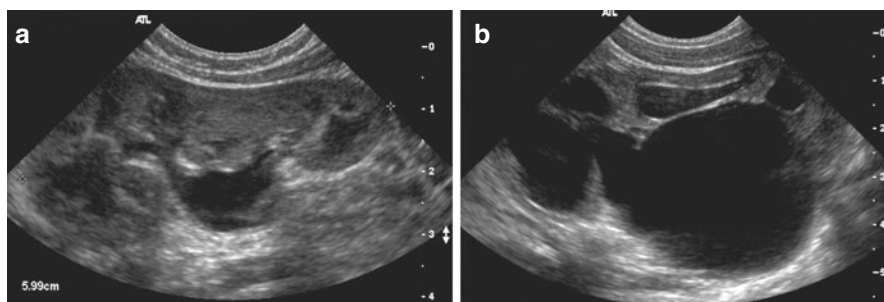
Renal ultrasound demonstrating (a) mild right hydronephrosis and (b) severe left hydronephrosis, consistent with a left ureteropelvic junction obstruction (UPJO)
